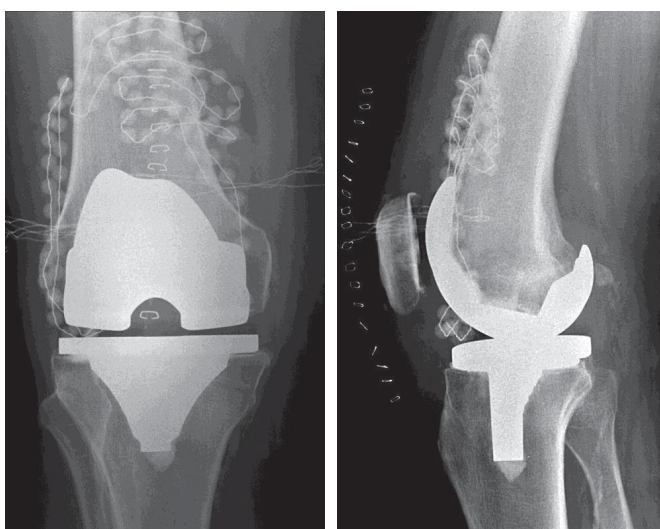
Radiographic appearance of a TKR in 2 directions. Gentamicin-PMMA beads are visible in the suprapatellar bursa and on the lateral side of the joint. Beads cannot be positioned in the posterior joint due to the limited space.
